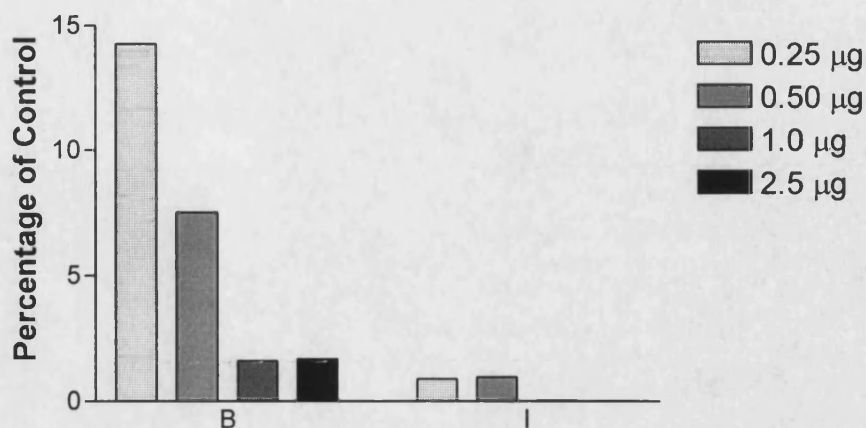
Western Blotting with Anti-Rac-CT of Cell Lysate from 3T3-L1 Adipocytes that was Subjected to Immunoprecipitation with Different Quantities of anti-Akt1(C-20).
